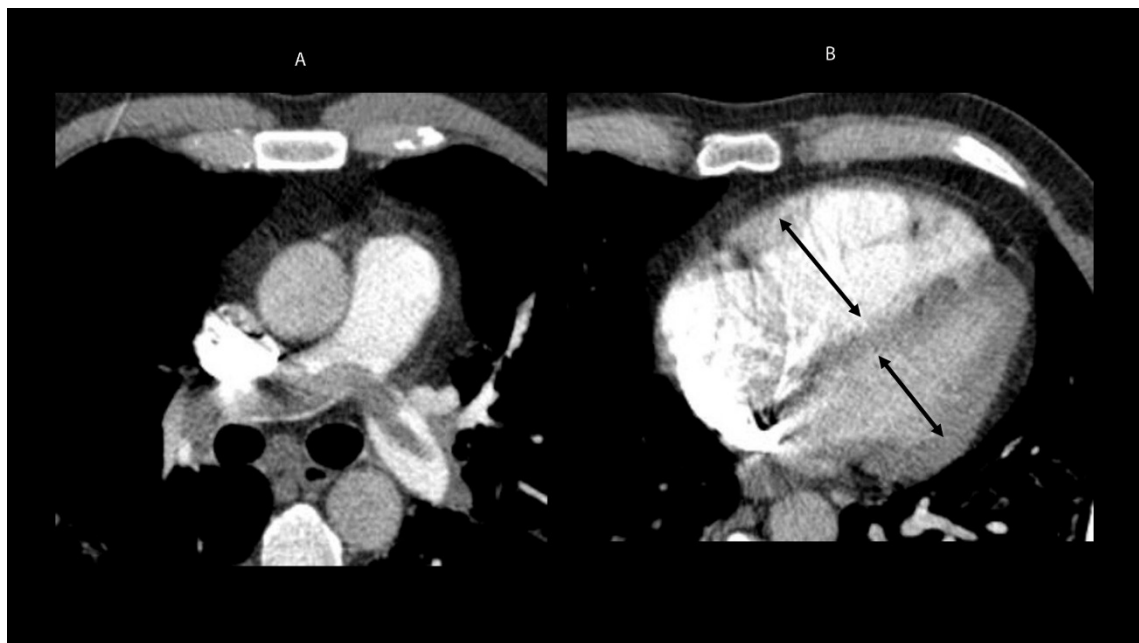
CT pulmonary angiography. A: typical signs of acute PE; B: signs of overload of the right heart chambers. Note RV/LV ratio >1.0 and straightening of the interventricular septum.
